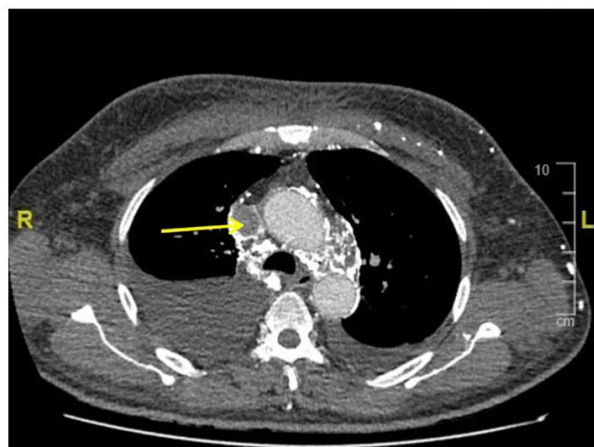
CT Thorax axial view: yellow arrow showing the thrombus in the superior vena cava
